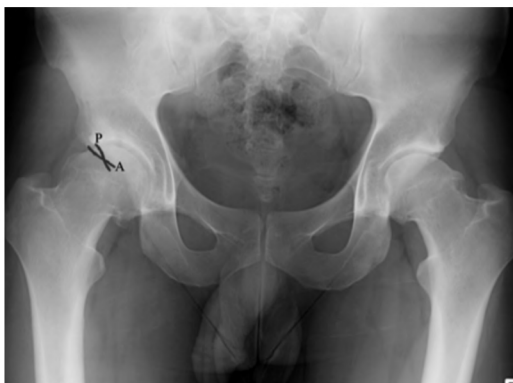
Plain X-ray AP of the pelvis shows the cross over sign in patient with pincer type (FAI).
